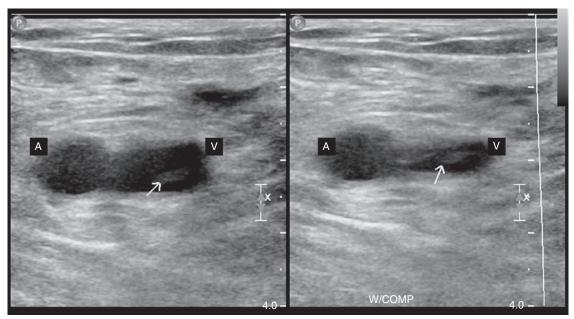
Deep Venous Thrombosis Diagnosed by Ultrasonography. In the left panel, an intraluminal thrombus is visible in the right common femoral vein (*arrow*). The right panel shows incomplete collapse of the femoral vein due to the presence of a clot. *A*, Femoral artery; *V*, femoral vein.
